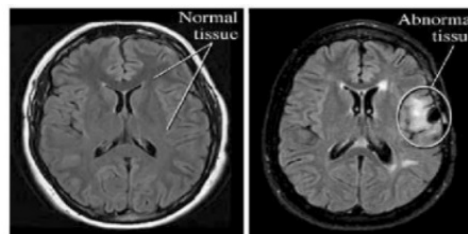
Magnetic Resonance Image of patient highlighting normal tissue and abnormal tissue
